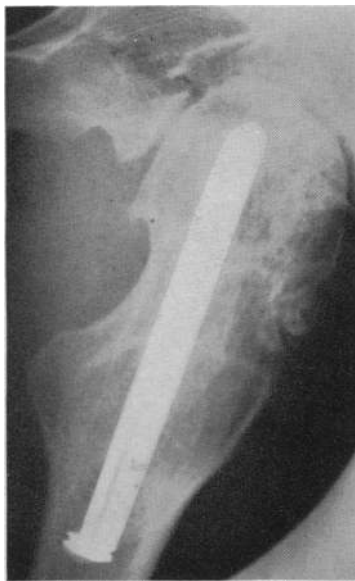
Nail A.460. Lateral radiograph of left hip. Note corrosion pits in distal third of nail and zone of reaction in bone.
